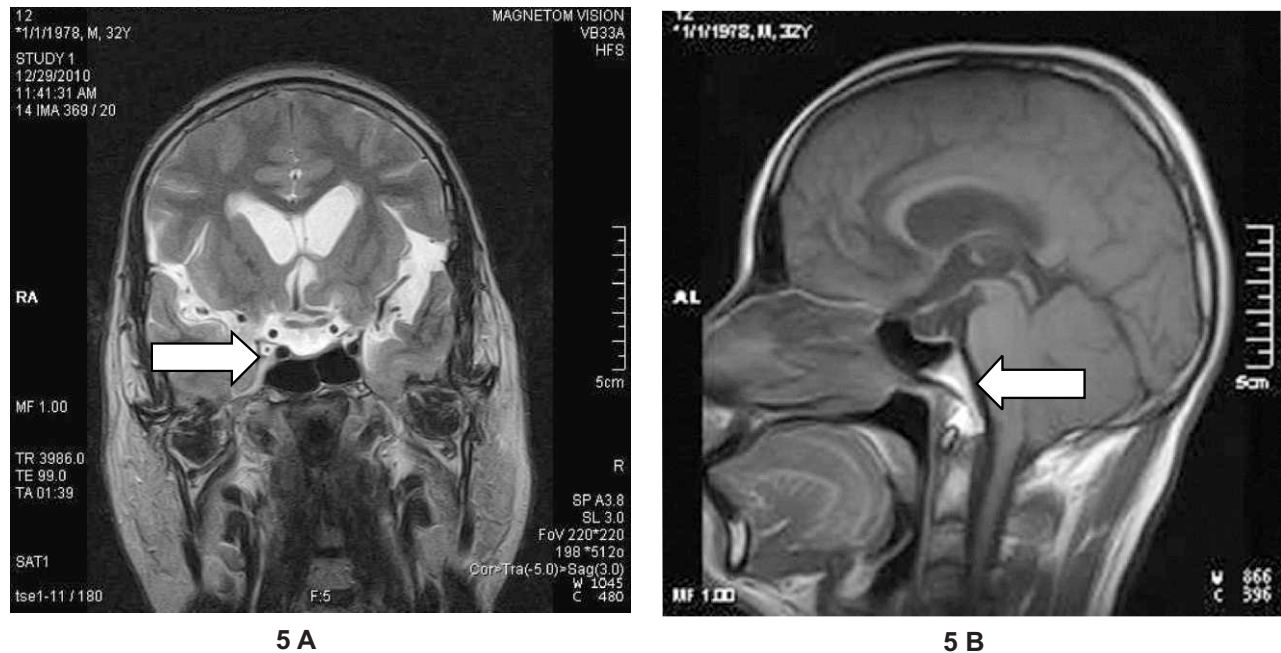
& 5B : MRI coronal T2WI and sagittal flair images of the Brain showing empty sella as discussed in Case 5.
